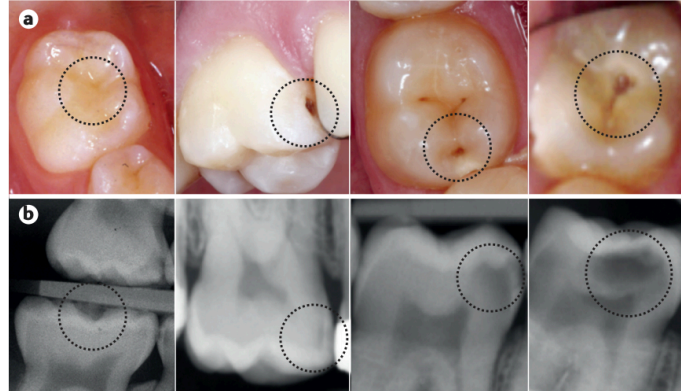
Clinical appearance (a) and corresponding bite-wing radiograph (b). Extracted from Nigel B. Pitts et al. (6)
